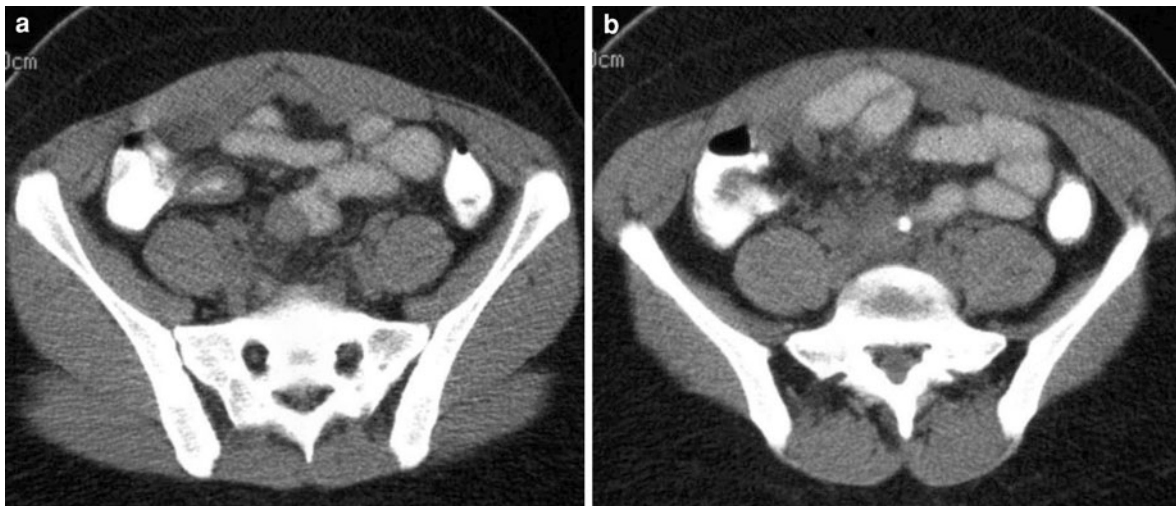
Metastatic appendiceal carcinoid tumor. Contrast-enhanced CT images show (a) diffuse appendiceal wall thickening and (b) infiltrative soft-tissue and focus of eccentric
